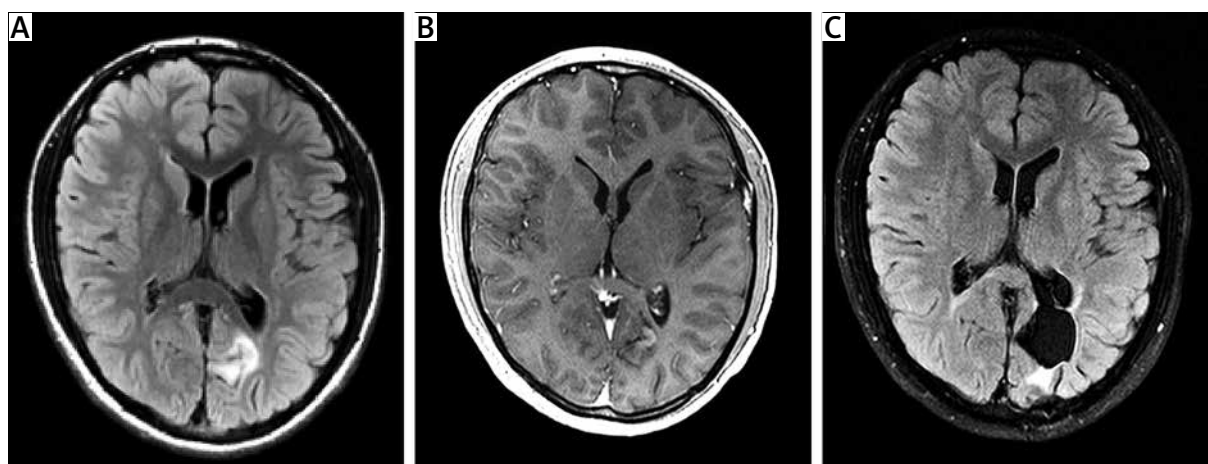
MRI feature. Case 2. A) Preoperative MR brain examination. Axial FLAIR image showing a cortico-subcortical mass with high signal intensity, involving the left parieto-occipital lobes, without mass effect. B) Preoperative MR brain examination. Contrast-enhanced axial T1-weighted image at the same level showing a slight enhancement of a part of the tumour. C) Post-operative MR images. Axial FLAIR image showing a well-delineated resection cavity.
